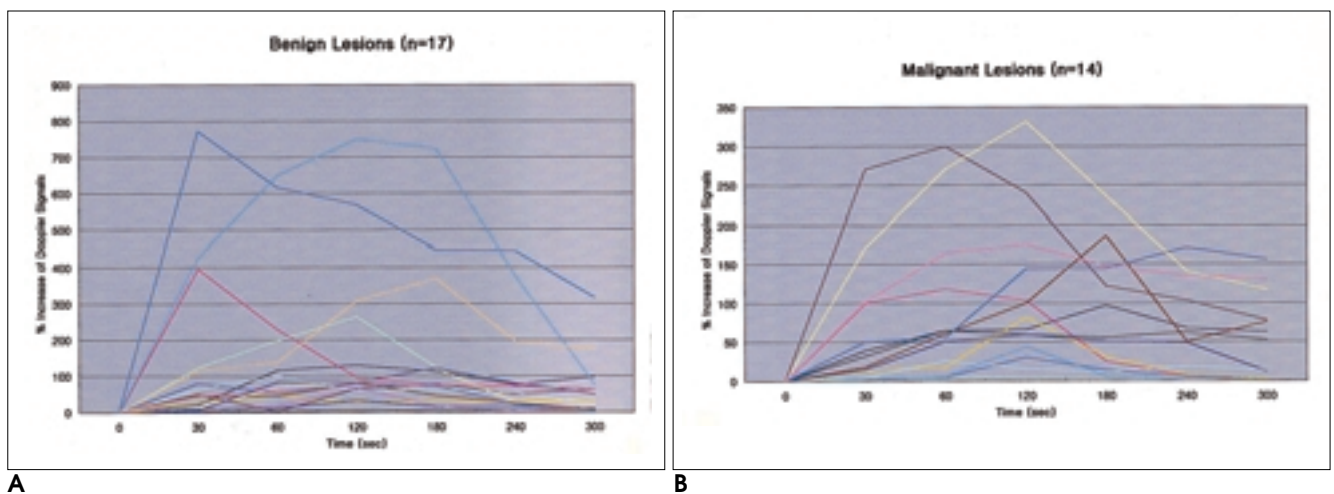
Time to percent increase of Doppler signals on contrast enhanced power Doppler ultrasonography in benign (A) and malignant (B) lesions.
